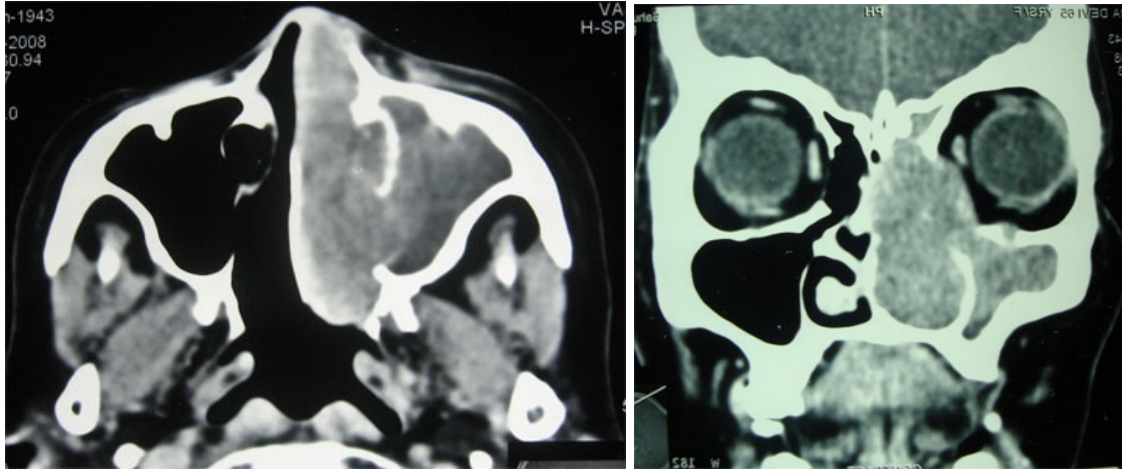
CT scan (Axial & Coronal) shows an enhancing soft-tissue mass occupying the left nasal cavity along with maxillary and ethmoid sinuses.
